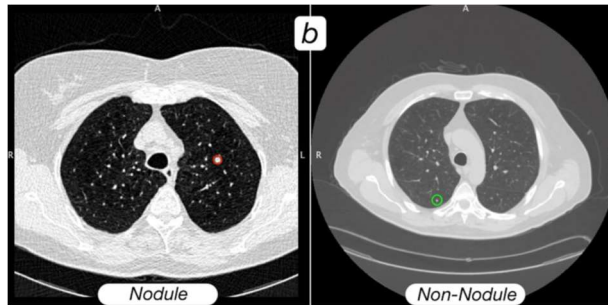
Sample of nodule and Non nodule CT scan Image
